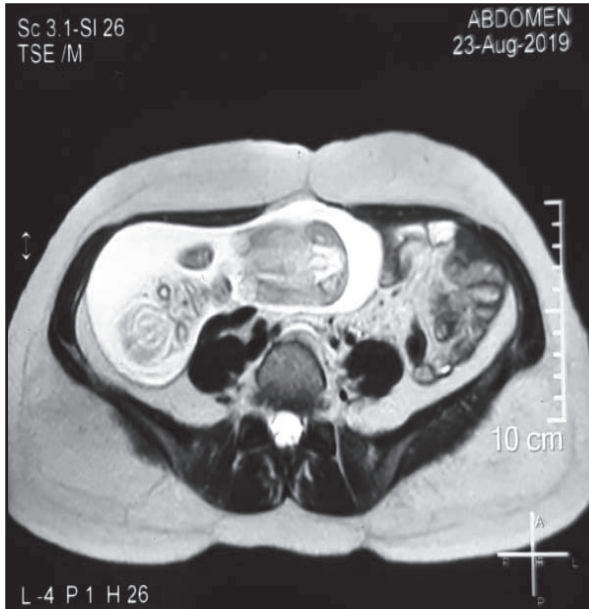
MRI(axial view) showing extrauterine pregnancy laying in abdominal cavity not surrounded by myometrium
